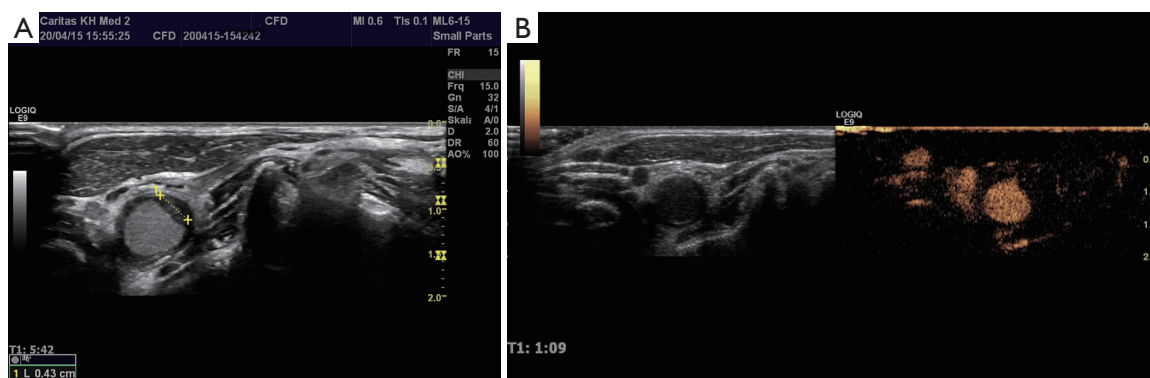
Small hematoma of the vessel wall following inadvertent puncture of the common carotid artery. (A) B-mode; (B) CEUS: the vessel lumen is not occluded. CEUS, contrast-enhanced ultrasound.
